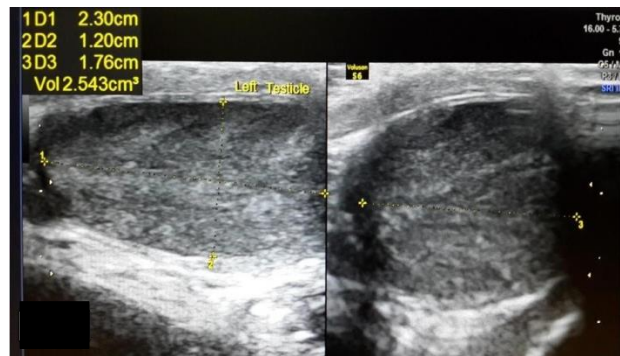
An ultrasonography image shows testicular atrophy with heterogeneous echotexture in a chronic alcoholic person.
